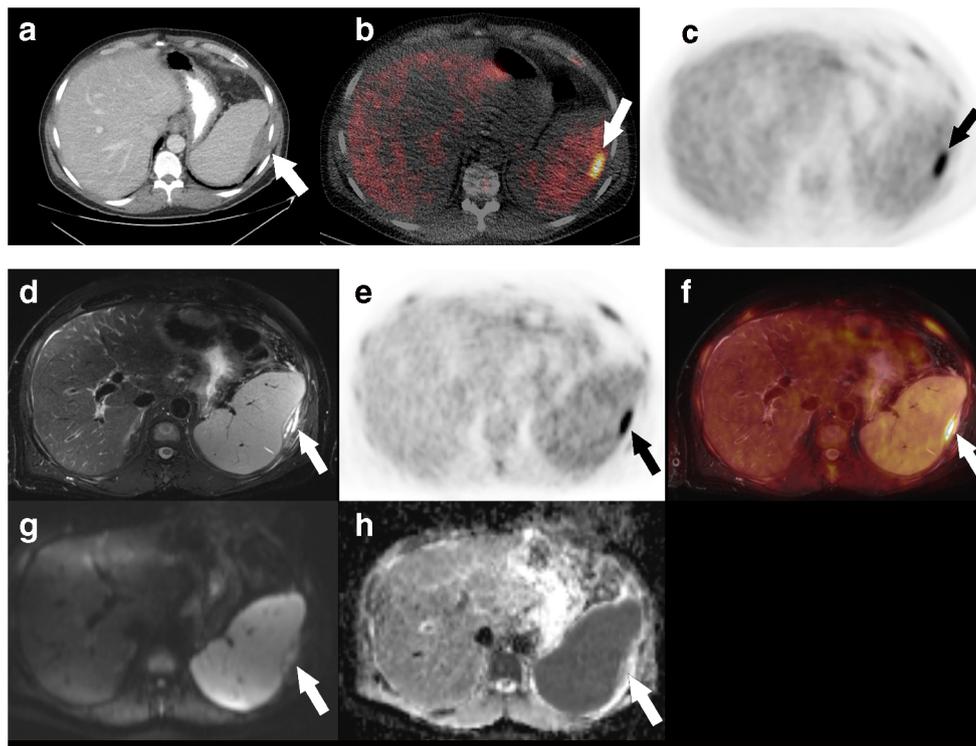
Downstaging based on PET/MR making patient resectable. 53-year-old male, with treated rectosigmoid adenocarcinoma with suspicious recurrent disease in the liver and perisplenic peritoneum. CEA was not elevated (1.0 ng/mL; normal values < 3.4 ng/mL). Axial CE-CT (a) and NCE-PET/CT (b fused PET/CT; c PET) showed a lenticular-shaped metabolically avid lesion (arrow) indenting the spleen, consistent with peritoneal metastasis. In this case, surgeons considered that the peritoneal
